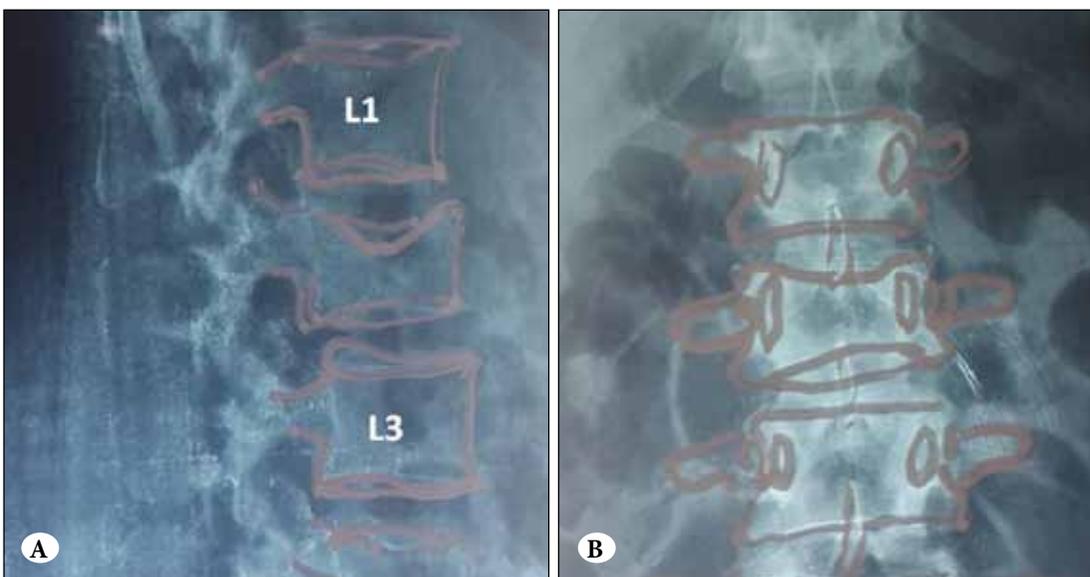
Lumbar plain radiographs: A, B) lateral and AP views showing compression fracture of second lumbar vertebra. The superior end plate is collapsed.
